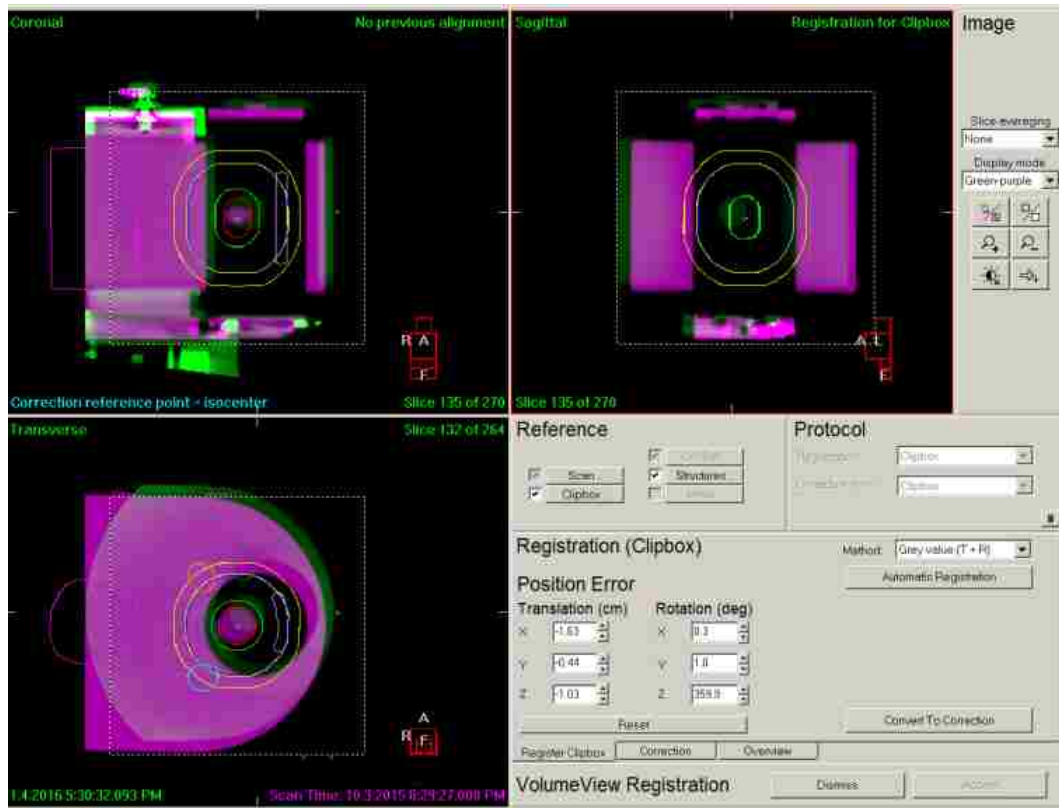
Screenshot of XVI 3D-kVCBCT registration window. (Green: Acquired CBCT; Purple: Pinnacle Export)
